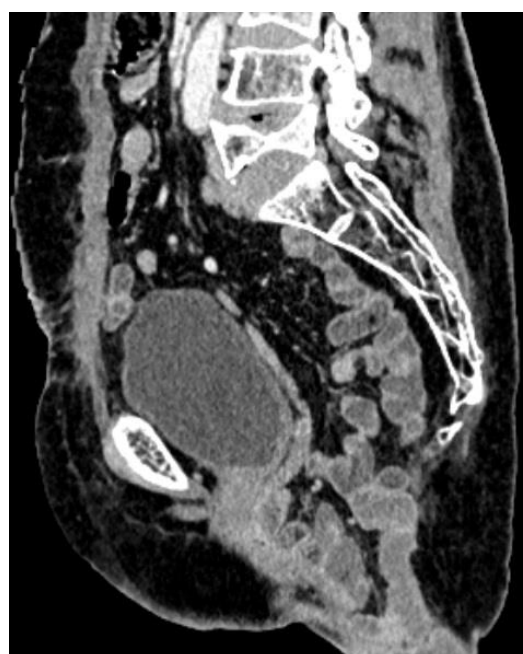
CT scan of pelvis objective the protrusion of the small bowel through the pelvis defect
